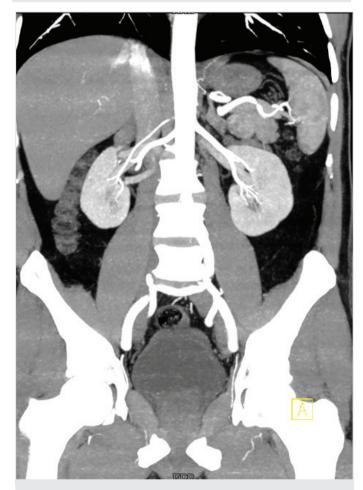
Coronal section of abdominal computed tomography angiography; multiple renal veins (arrow), polar renal artery (arrowhead)
